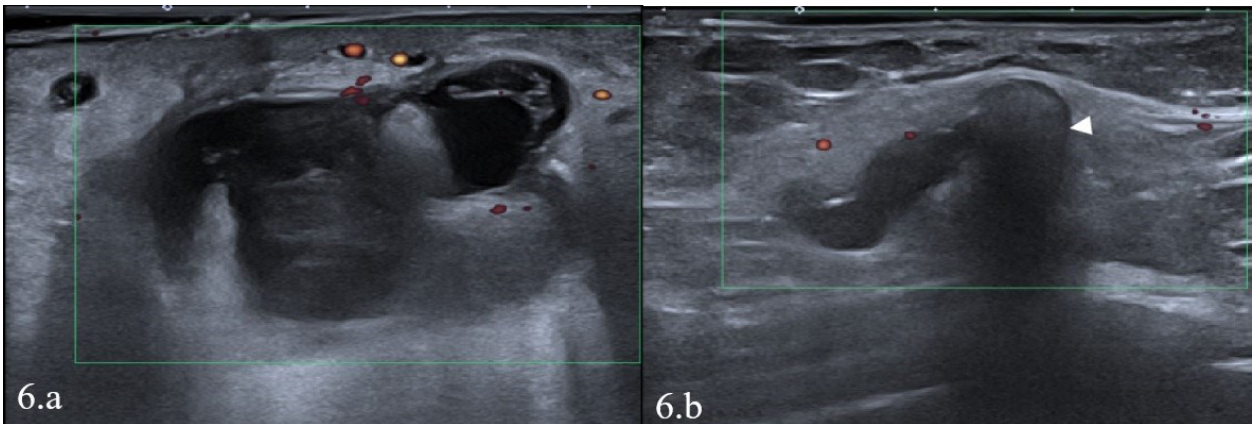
Control ultrasonography 1 week post-intervention. The pseudoaneurysm was completely thrombosed. A dirty acoustic shadowing was observed in the lumen due to the embolization of the injected contrast material with other collateral vascular structures; moreover, no flow was observed in the Doppler examination.
